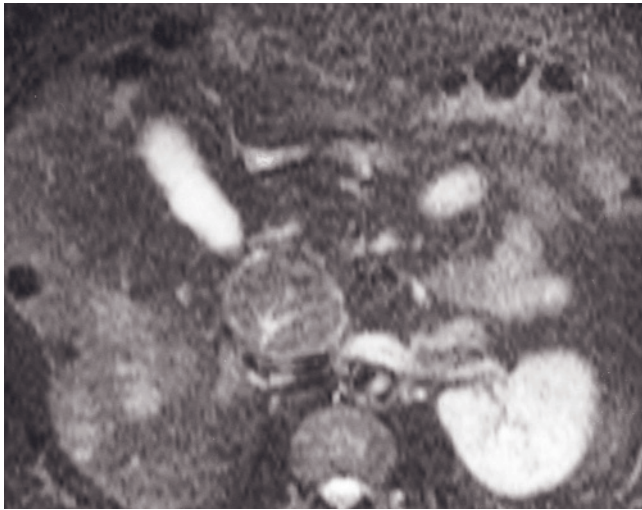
(Continued) echo train-STIR (*e*) and 90-s fat-suppressed postgadolinium SGE (*f*) images; and 90-s fat-suppressed postgadolinium SGE images (*g*, *h*) in three patients with porta hepatis lymph nodes (arrows, *a*, *b*, *g*, *h*). The lymph nodes in the porta hepatis are best detected by the combination of identification of high-signal tissue on T2-weighted fat-suppressed images (*a*, *b*, *e*) and demonstration that the high-signal tissue has definable convex margins on interstitial-phase gadolinium-enhanced fat-suppressed SGE images (*c*, *d*, *f*, *g*, *h*). All of these patients have chronic hepatitis or cirrhosis. Enlarged porta hepatis lymph nodes are common in patients with chronic liver disease, especially secondary to hepatitis C infection.
